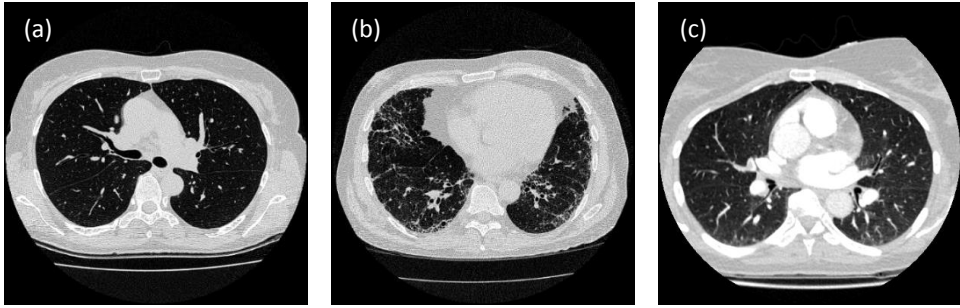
Slices of HRCT scans from a normal case (a), a patient with ILD (b), and a slice of CTPA from a patient in CTEPH.
